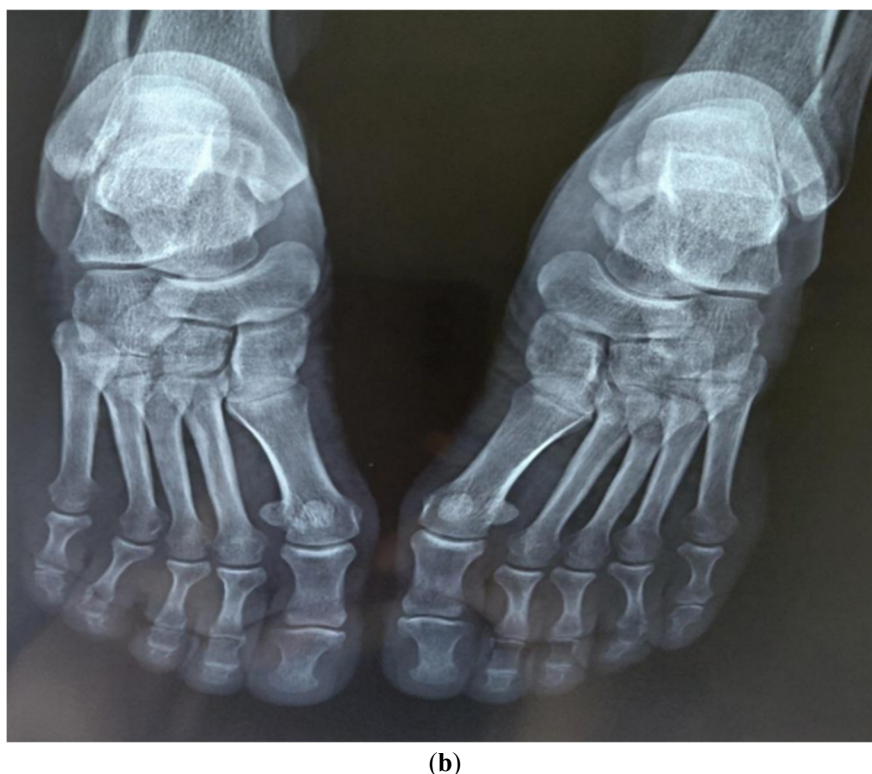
(a) Radiograph of the hands demonstrating sarcoid acropachy, with distal phalangeal soft tissue swelling, mild periarticular erosions, and periosteal changes typical of granulomatous involvement. (b) Sarcoid acropachy of the toes, demonstrated by distal phalangeal swelling and periarticular changes on radiography.
